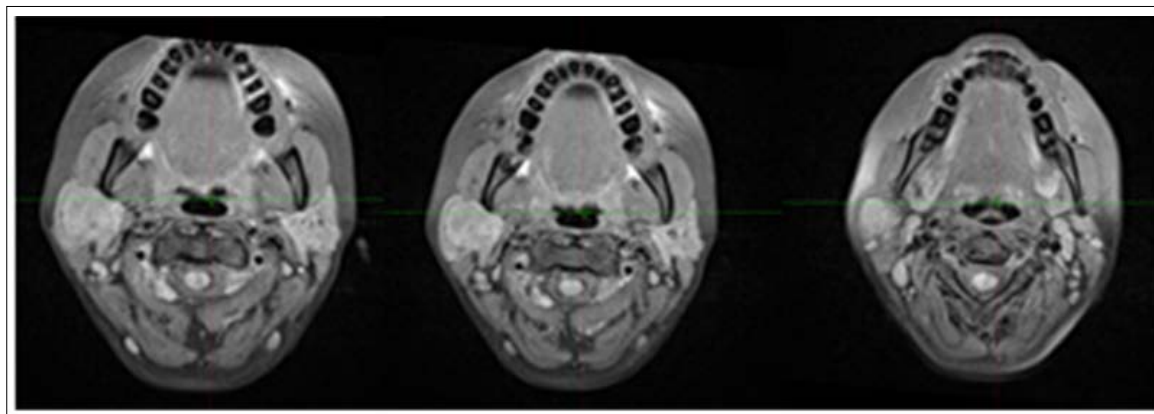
MRI from 09/19/23
